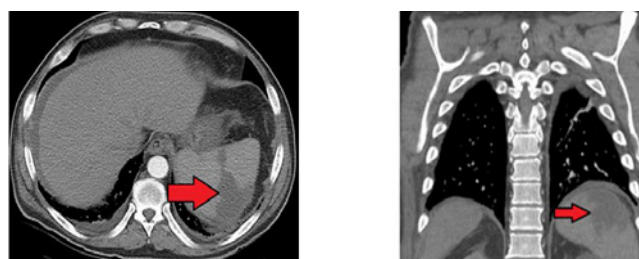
CT Abdomen showing a splenic infarct with a left pleural effusion and left lower lobe atelectasis.
